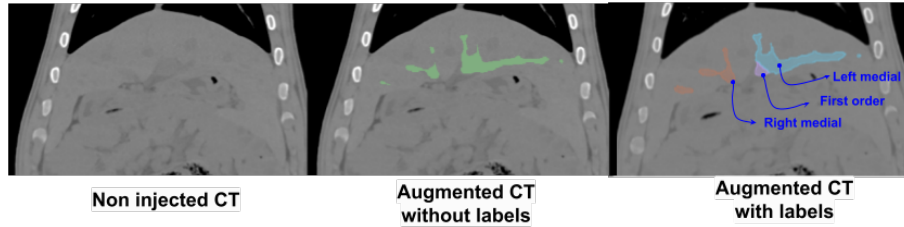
In this figure we show the original NCCT on the left. The middle image shows the augmented CT with the predicted vessel tree (in green). The rightmost image shows the augmented image with anatomical labels transferred from the preoperative image segmentation and labelling.
